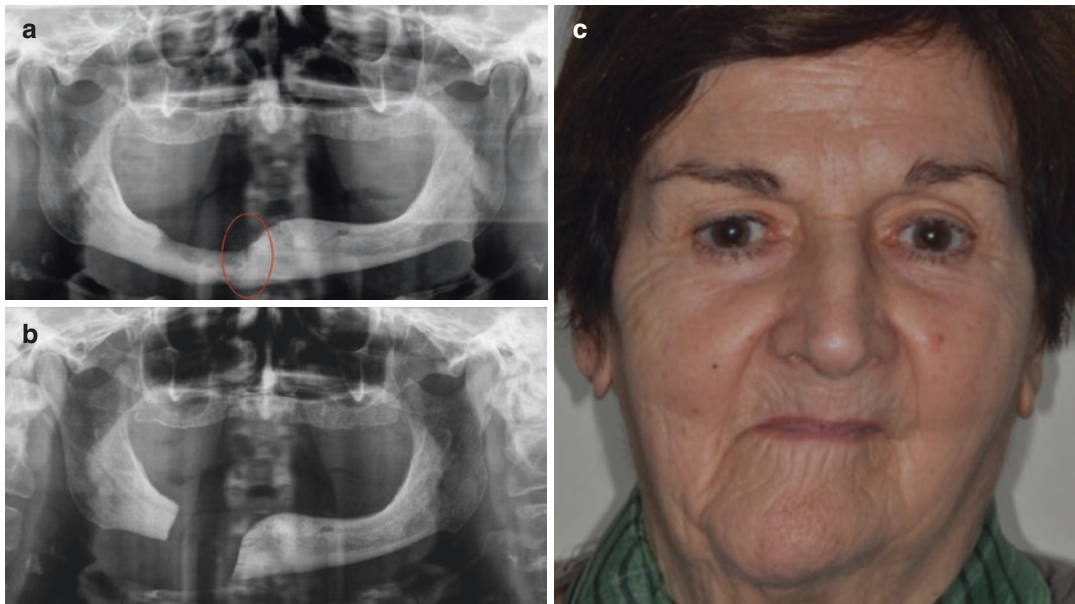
(a–c) Preoperative radiographs showing pathological fracture on the right mandible (stage 3) of a 73-year-old patient suffering osteoporosis. She underwent segmental mandibulectomy without immediate reconstruction
